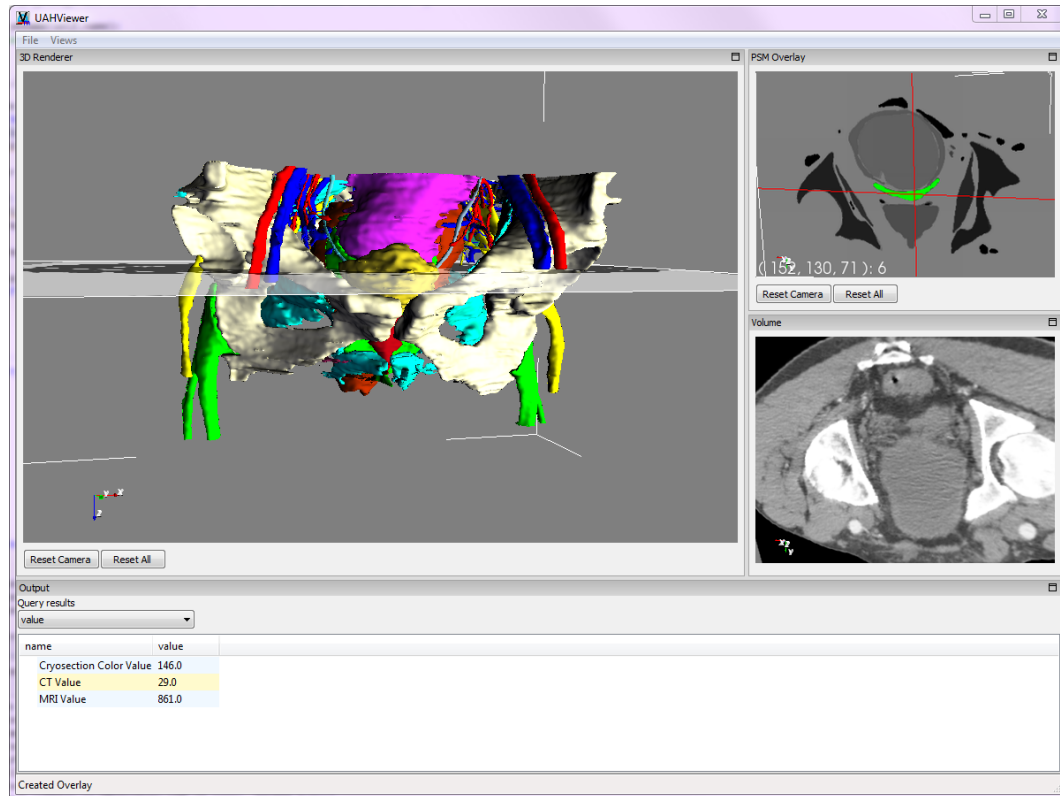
Value querying in arbitrary views presents query results for all available volumes in that point. The surface render shows an MRI slice while the top right render window displays the linked segmentation label volume slice and the lower right render window displays the mapped CT slice
